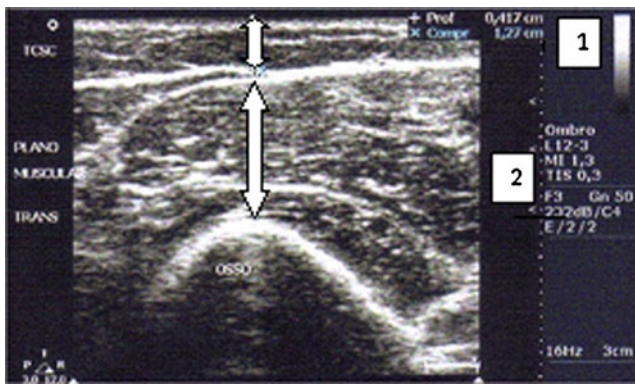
Ultrasonic evaluation of the right upper limb in the transverse plane. Arrows: 1 thickness of the subcutaneous adipose tissue and 2 thickness of the muscle
